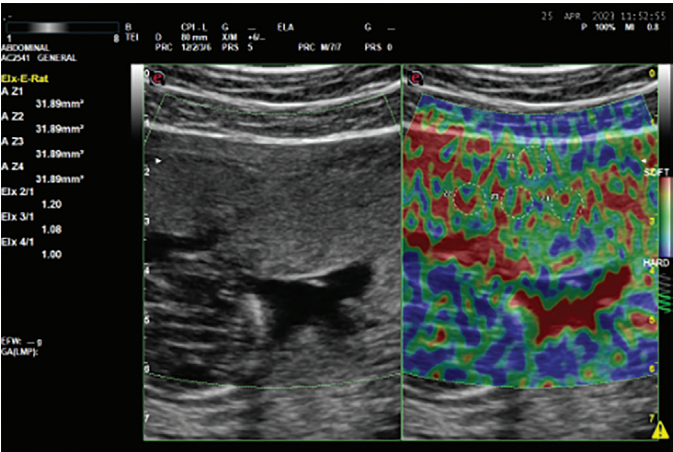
Ultrasound image of placental sonoelastography
